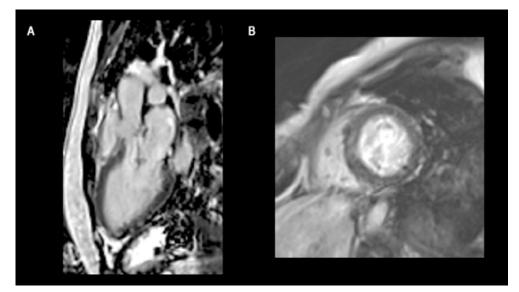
Late gadolinum enhanced magnetic resonance images of the heart. Post-contrast high resolution inversion recovery magnetic images of A) 3-chamber and B) basal short axis views do not show any late gadolinium enhancement to suggest myocardial infarction, or any regional wall motion abnormalities. The sinotubular junction was also noted to be narrowed at 13 mm, whereas the annulus was 18 mm and the sinus of Valsalva was 22 mm. The peak gradient across the supra-aortic and aortic valve segments was 63 mmHg.
